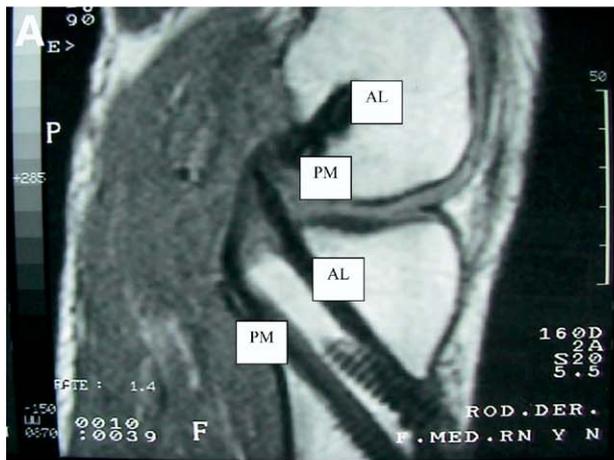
(A) Magnetic resonance image of the double-double tunnel reconstruction. (B) Arthroscopic view through posteromedial portal, in the tibial footprint of the PCL. See tibial guide inserted to avoid vascular lesion.
